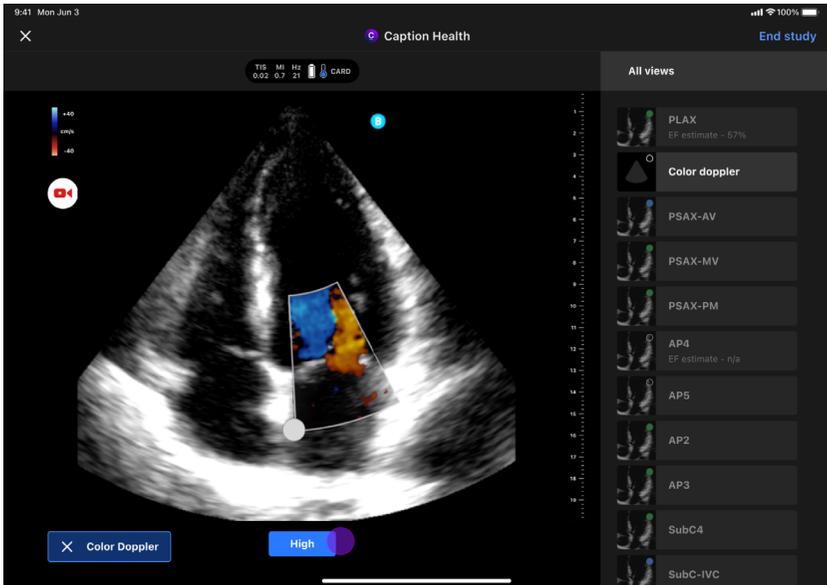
Scanning screen: Color Doppler mode
